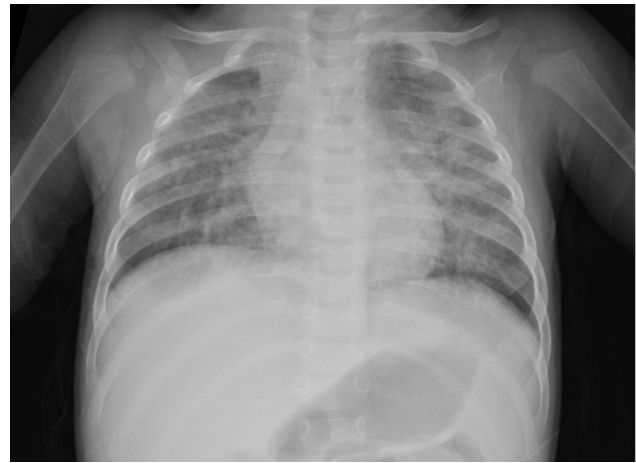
Chest radiograph for Case 2.
